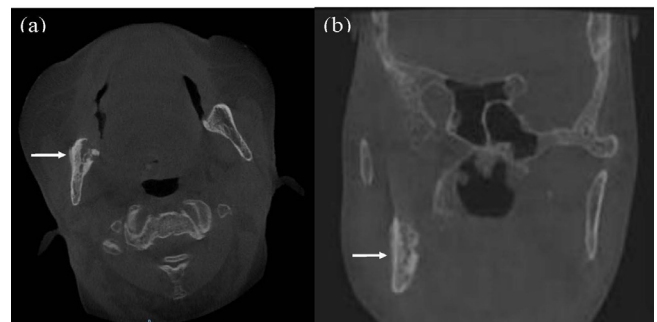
Cone beam CT showing a moth-eaten appearance of the right angle of the mandible and ramus with areas of osteolysis, sclerosis and bony sequestration in a) transverse view (arrow) and b) in coronal view (arrow).
